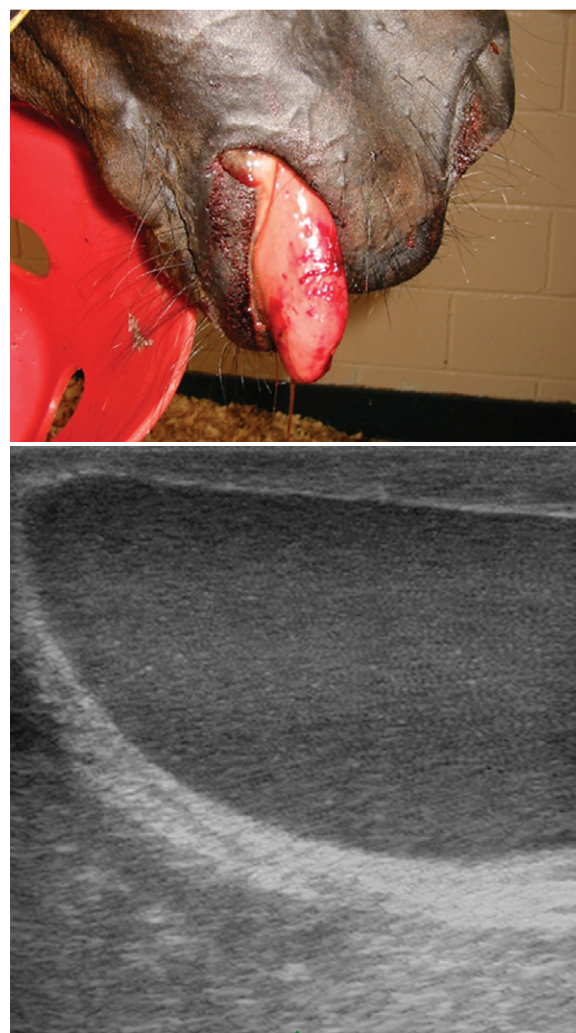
A, Swollen tongue secondary to foreign body penetration. B, Ultrasound image demonstrating large abscess in the tongue. (Courtesy Dr. Steeve Giguere.)
